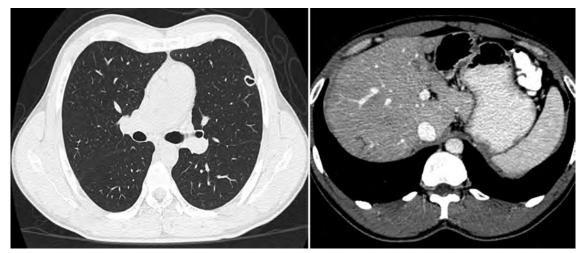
Follow-up CT scans showing resolving lesions
